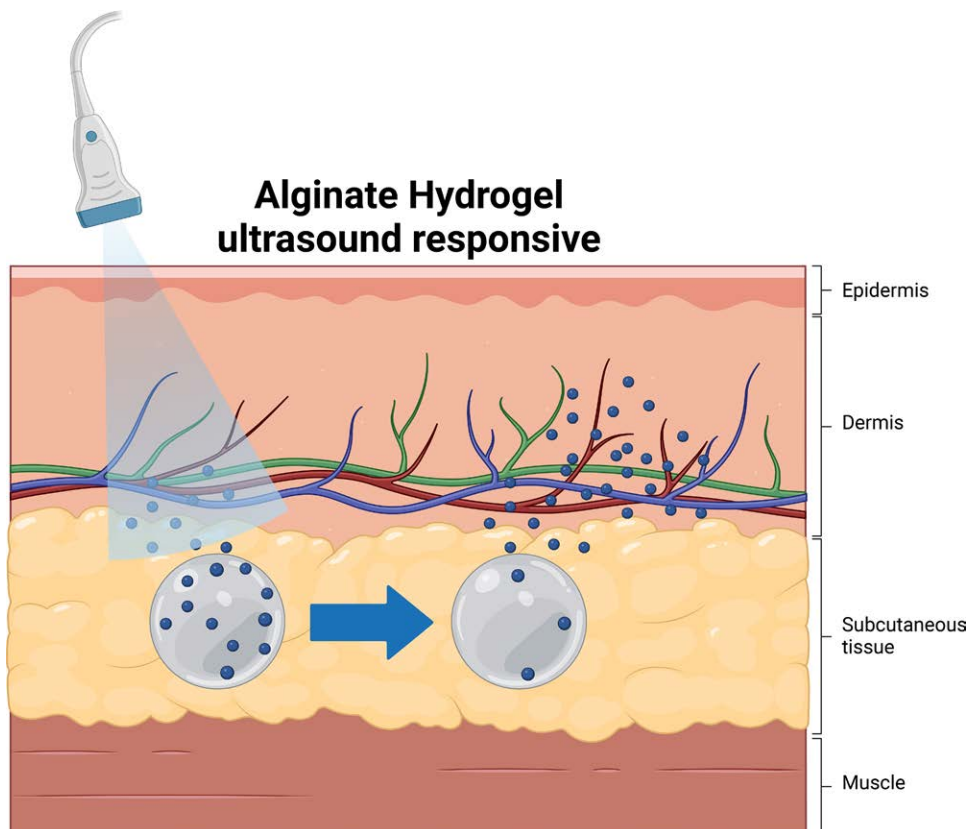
Mechanism of action of TAC-loaded ultrasound responsive hydrogel. While having continuous TAC release without stimulation in the therapeutic range, on-demand release of additional TAC can be achieved by ultrasound stimulation. Created with BioRender.com. TAC, tacrolimus.
